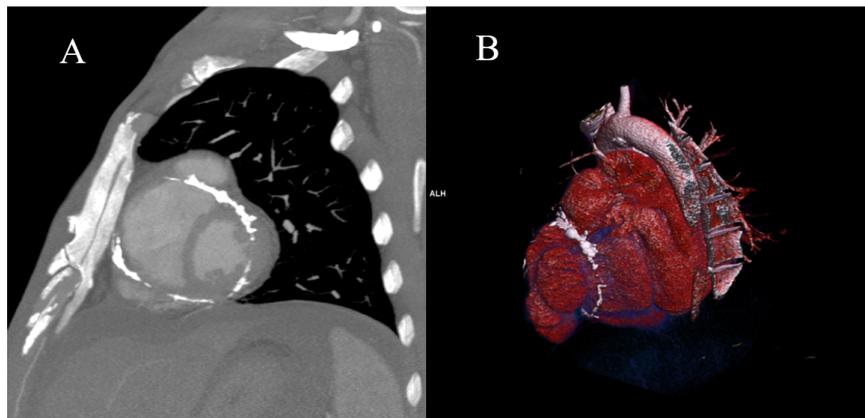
A and B: Chest Computed Tomography showed constrictive pericardium which was pericardial calcification
